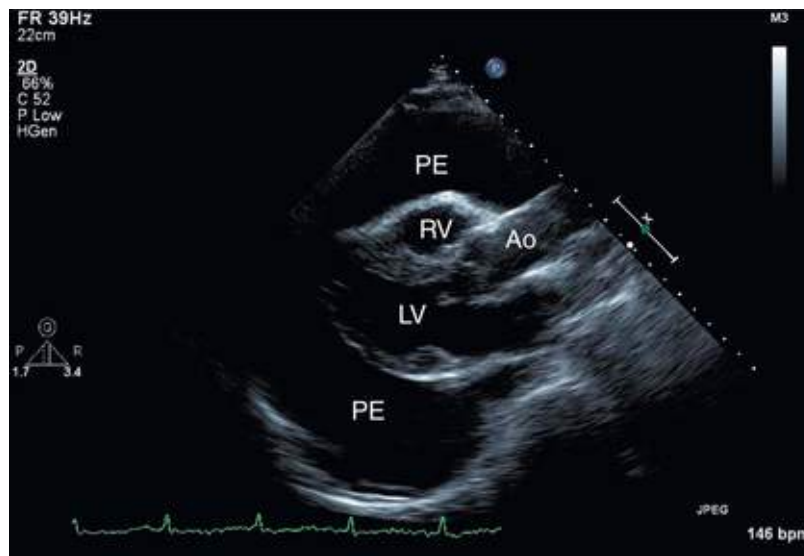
Two-dimensional echocardiogram of a large, circumferential pericardial effusion (PE). Ao, aorta; LV, left ventricle; RV, right ventricle. (From Kabbani SS, LeWinter M: Cardiac constriction and restriction. In Crawford MH, DiMarco JP [editors]: Cardiology. St. Louis, Mosby, 2001.)
